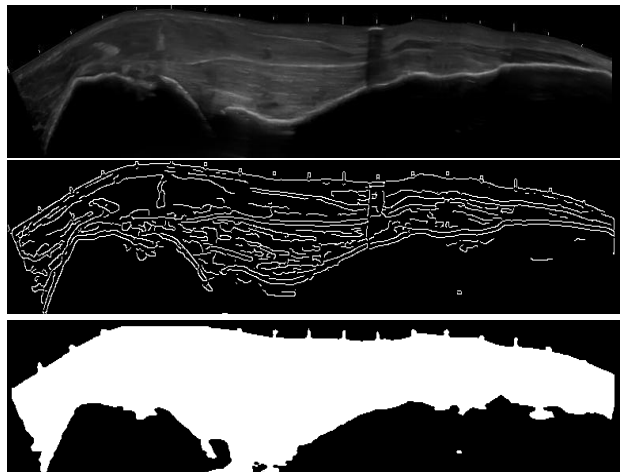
from top to bottom, input ultrasound image (sample4), CGT and output image.
